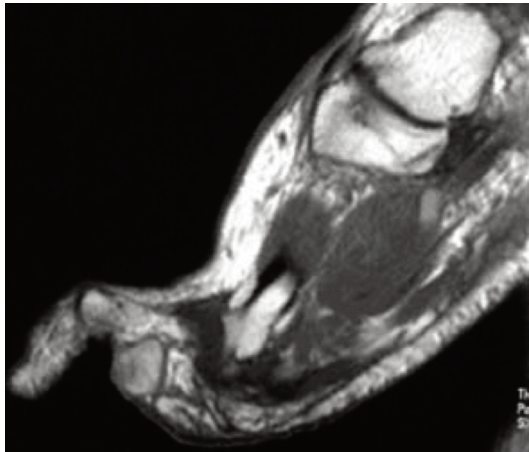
T1-weighted image demonstrating the hyperintensity of a metastatic malignant melanoma in the plantar tissues of the second intermetatarsal space.
